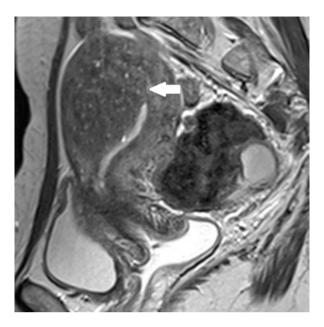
Adenomyosis. Sagittal T2-weighted MR shows poor delineation of the uterine zonal anatomy with marked thickening of the junctional zone within the anterior myometrium (white arrow). Multiple punctate hyperintense foci are noted within the myometrium, consistent with heterotopic endometrial glands
